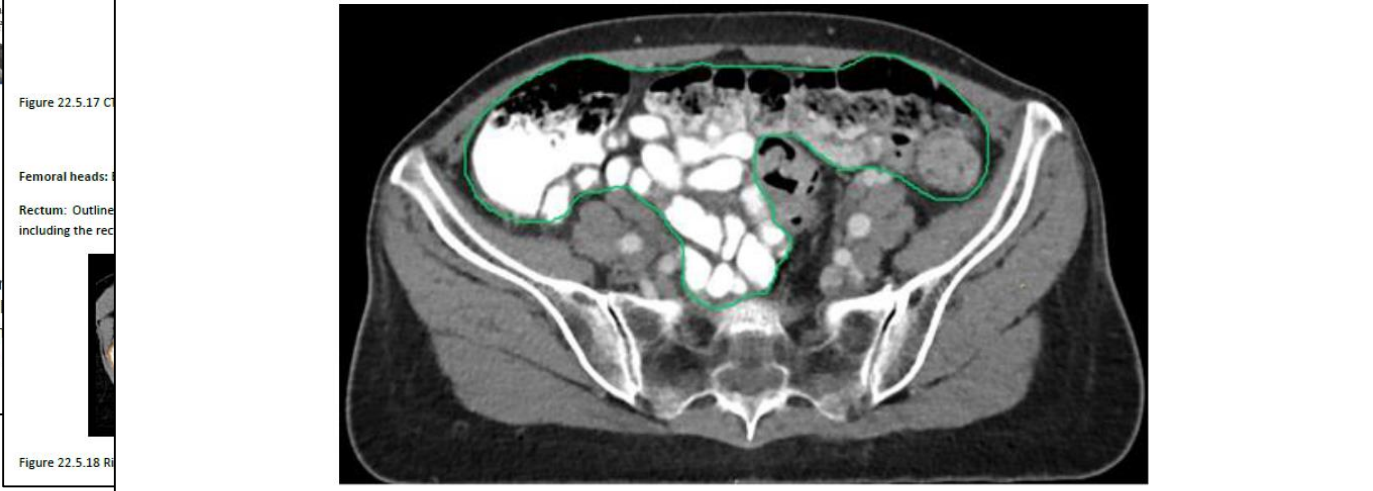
CT. bowel contour (green)
